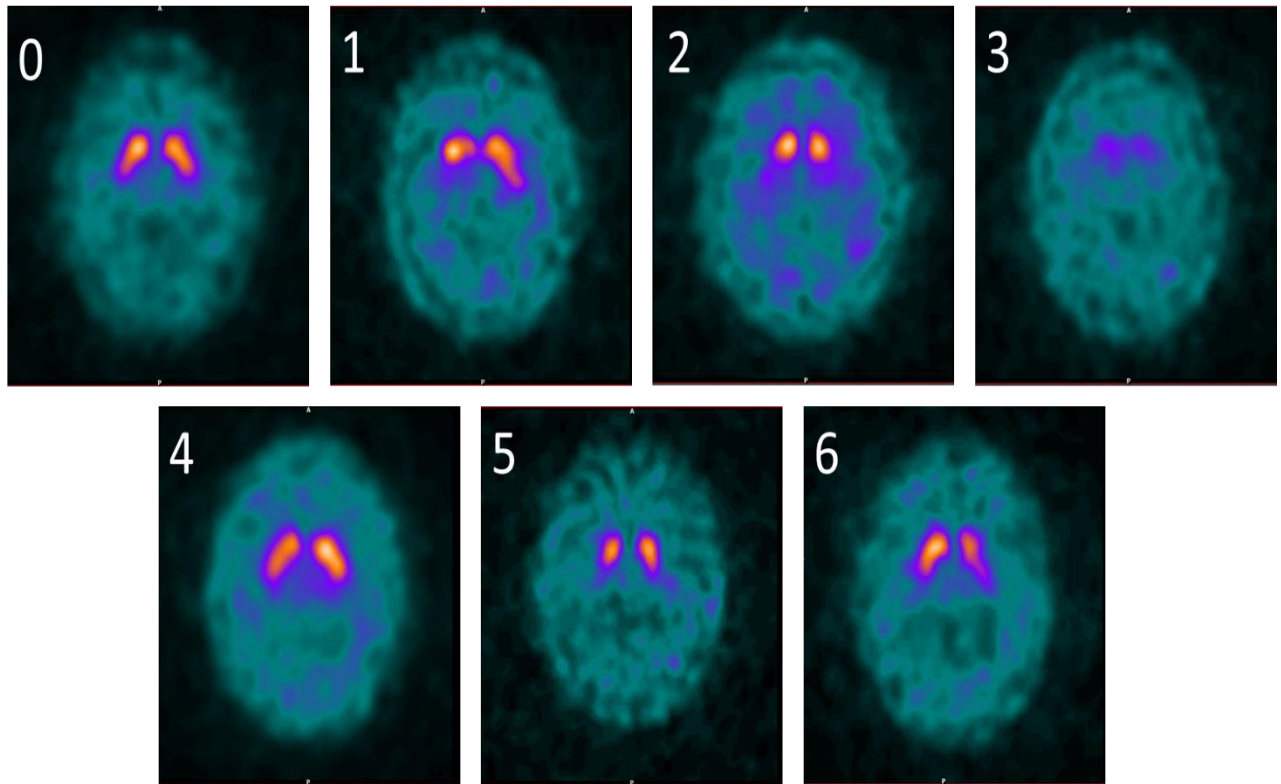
4 Visual assessment of  $^{123}\text{I}$ -FP-CIT SPECT using modified Benamer scale.
